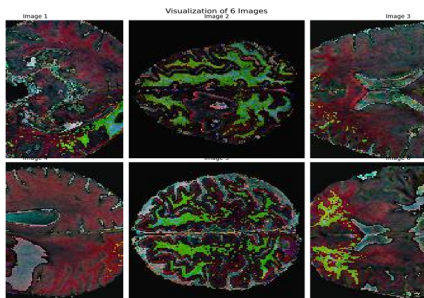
Sample MRI Images from Brain Tumor Detection Dataset.
